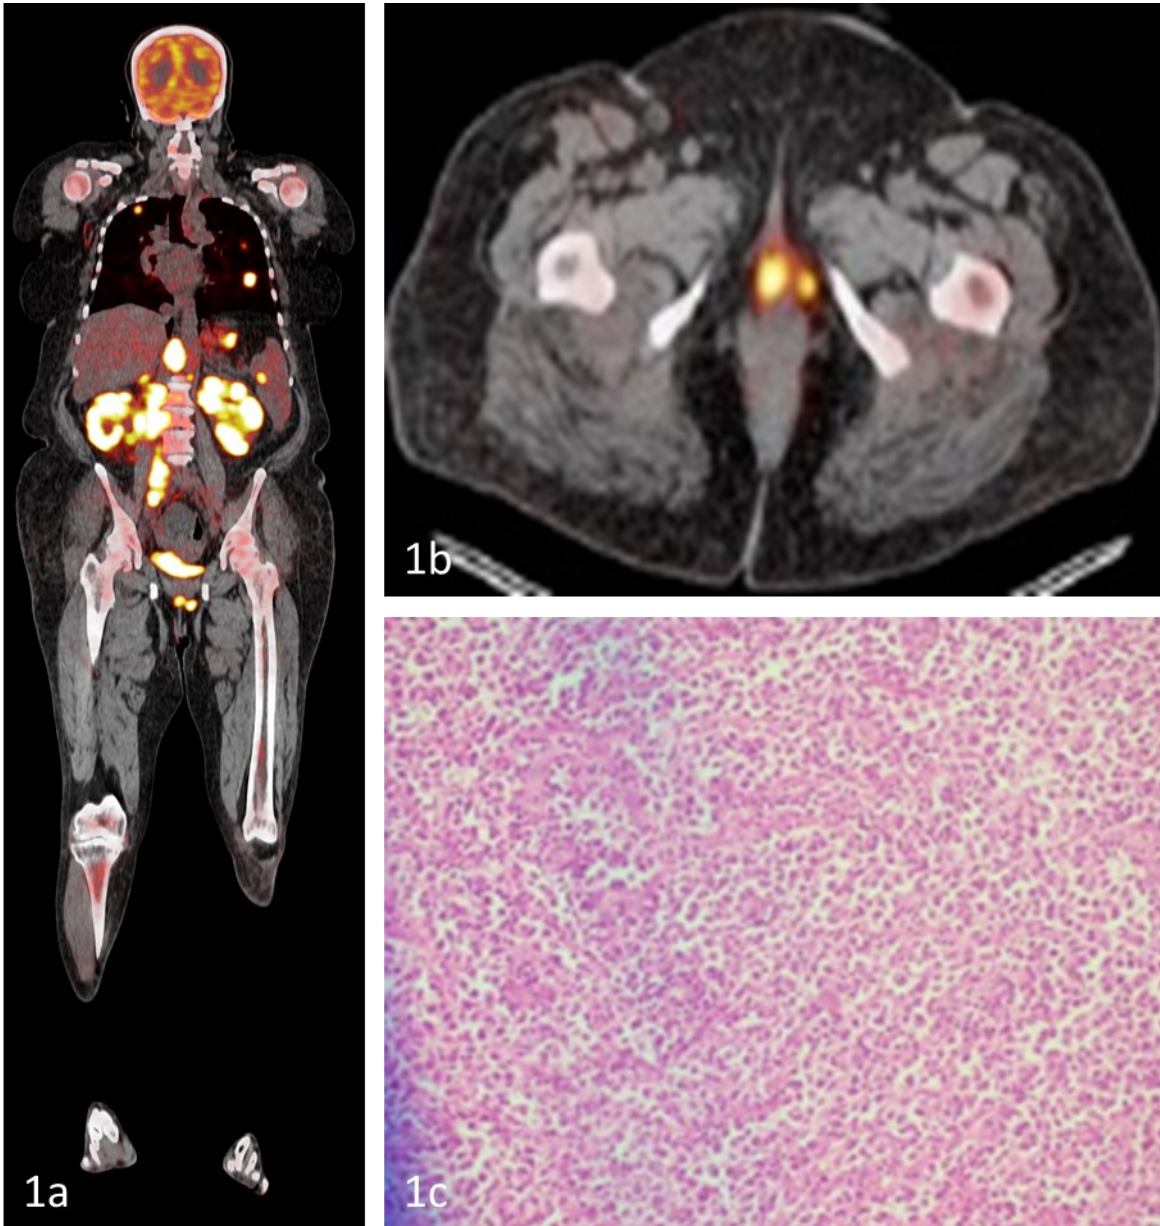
Whole body horizontal PET and CT fused image (Figure 1a) and transaxial plane image of vulva (Figure 1b).
